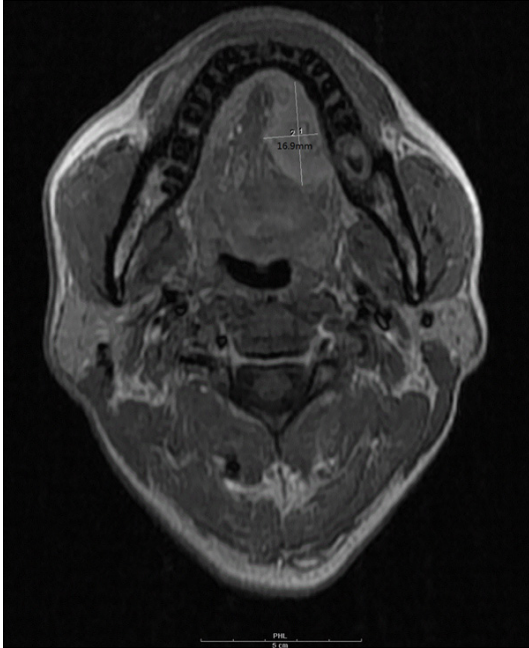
Invasion depth on MRI was defined on gadolinium-enhanced T1 weighted image.
